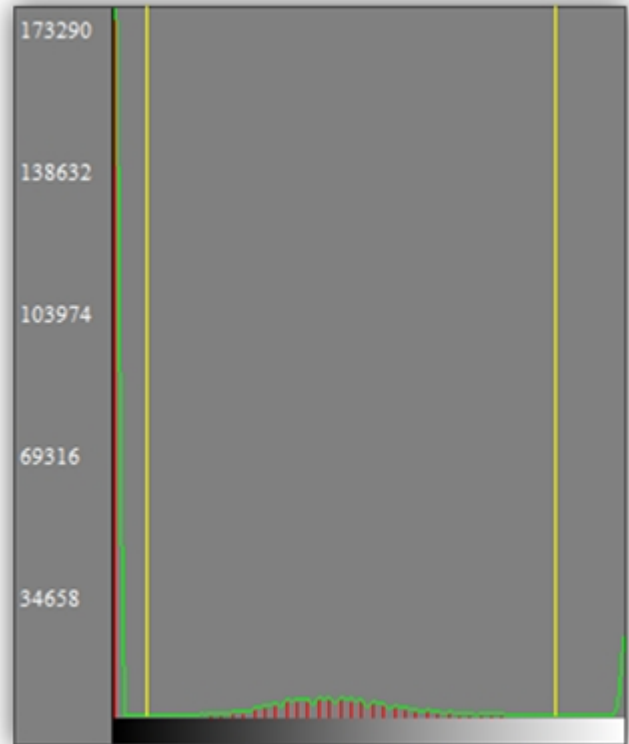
a histogram of a pre-enhanced CT Image
